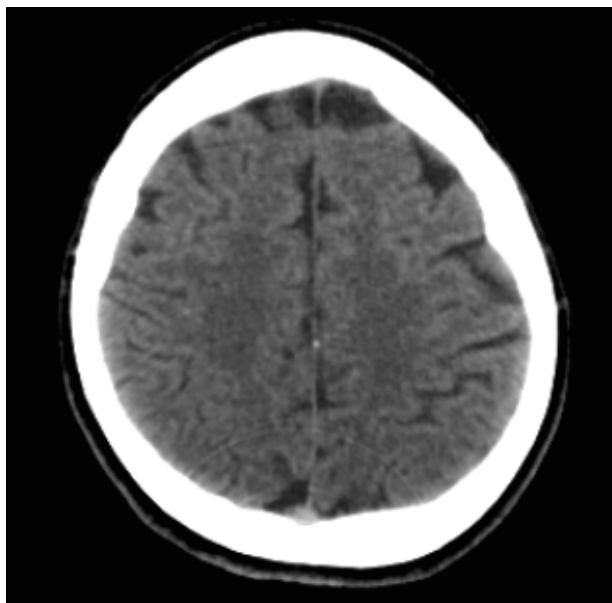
Non-contrast axial CT image shows cortical atrophy.
